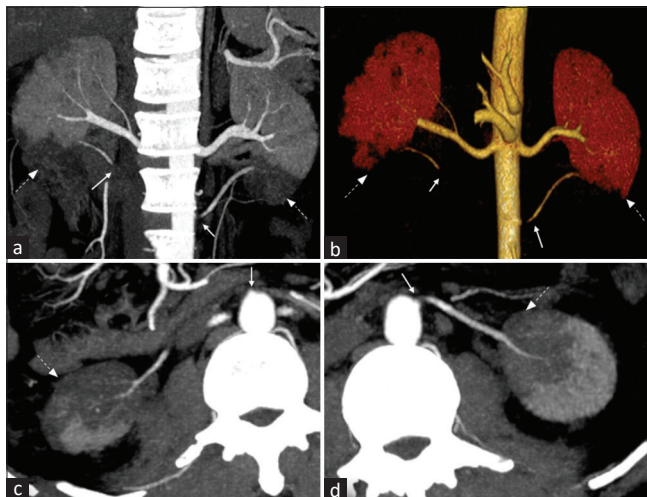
Images of CECT (Contrast-enhanced Computed Tomography) abdomen in the arterial phase of a 38-year-old-male patient with a history of blunt trauma abdomen showing bilateral aberrant renal artery thrombosis ((white solid arrows) just beyond the aberrant renal arteries's' origins from the aorta and segmental infarcts (white dashed arrows) in the lower poles of bilateral kidneys with normal main renal arteries. (a) MIP (Maximum Intensity Projection) coronal curved reformatted image. (b) Volume-rendered image. (c) MIP axial curved reformatted image along the axis of the right aberrant renal artery. (d) MIP axial curved reformatted image along the axis of the left aberrant renal artery
